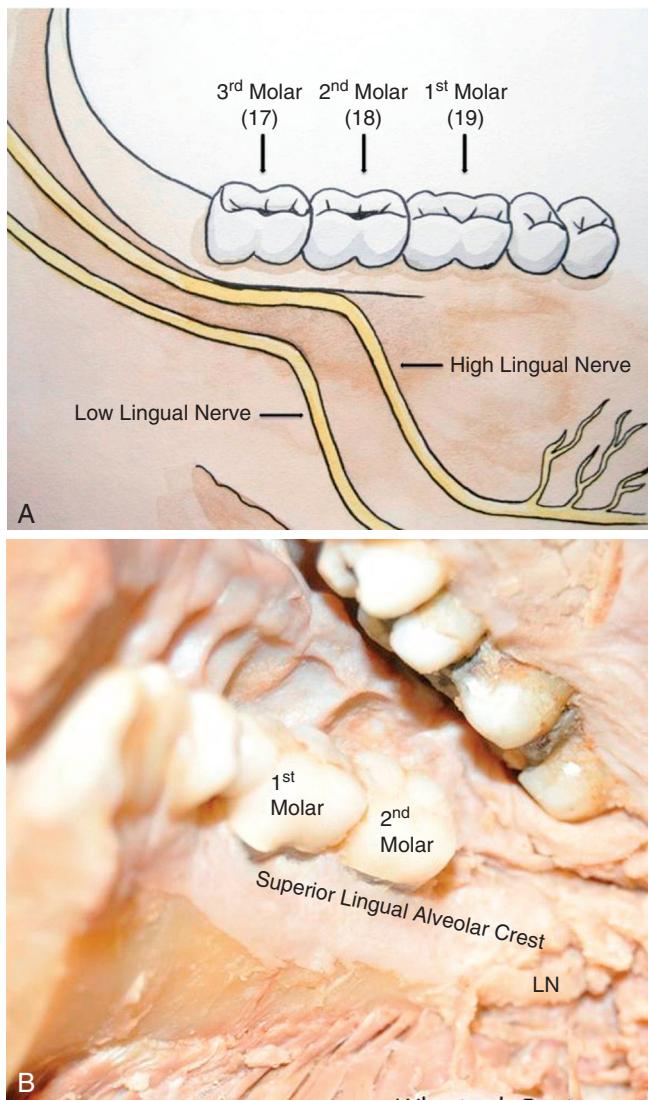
(A–B) Lingual nerve anatomy and variant positions. Note the proximity to the crest of the ridge in the “high” variant position. A lingually placed incision or excessive retraction may cause damage to the lingual nerve. (From Benninger B, Kloenne J, Horn JL: Clinical anatomy of the lingual nerve and identification with ultrasonography, *Brit J Oral Maxillofac Surg* 51:541–544, 2013.)
